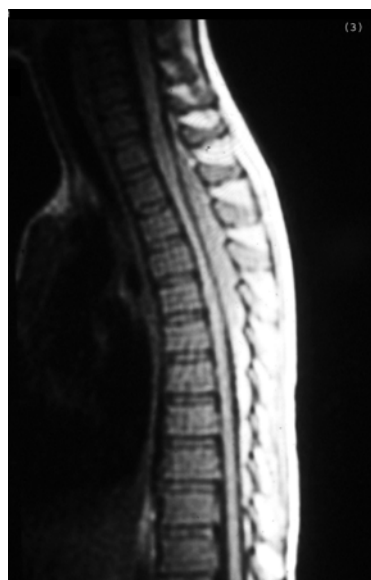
Sagittal T1-weighted MR image of the thoracic vertebrae showing an elongated epidural mass, compressing the thoracic spinal cord.
